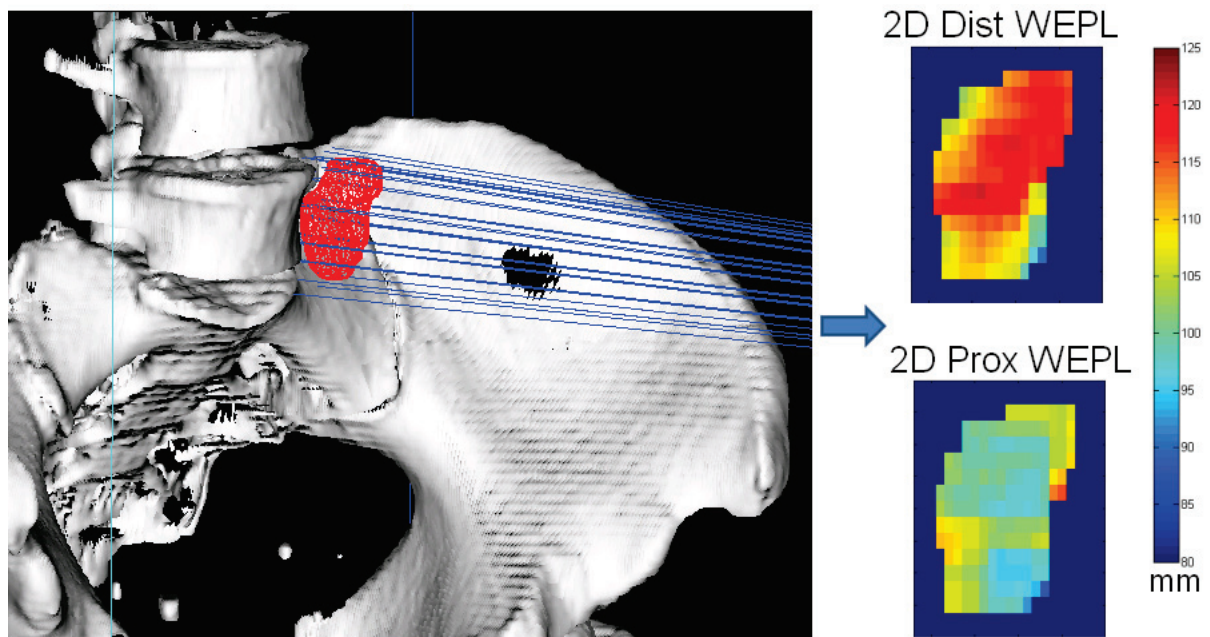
A ray-tracing method was used to determine the water-equivalent path-length (WEPL) from the patient surface to the distal and proximal edges of all targets. Ray tracing is parallel to the treatment beam direction. This method results in two 2-dimensional matrices that represent the distal and proximal WEPL map for each target on any particular computed tomography scan.
